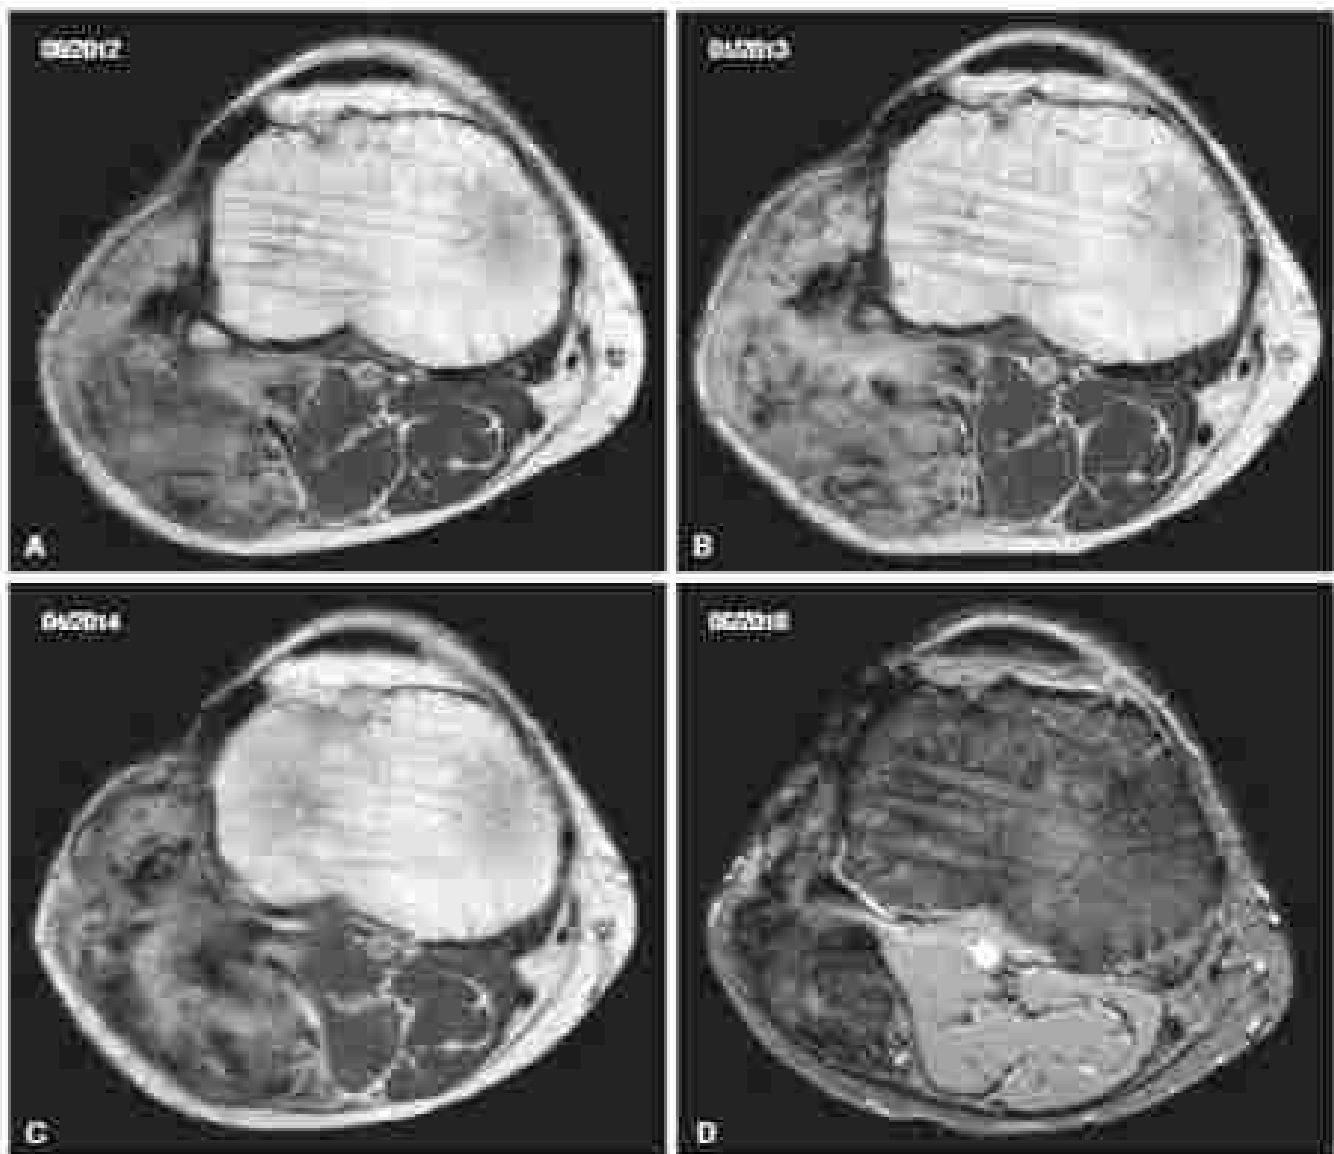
Axial T2-weighted T1-weighted magnetic resonance images of right proximal thigh fibrosarcoma in adult surveillance only at baseline (A), 5 months (B), 2+ months (C), and 76 months (D) later. A low regression after initial stage progression and subsequent stabilization at nearly 100%.
